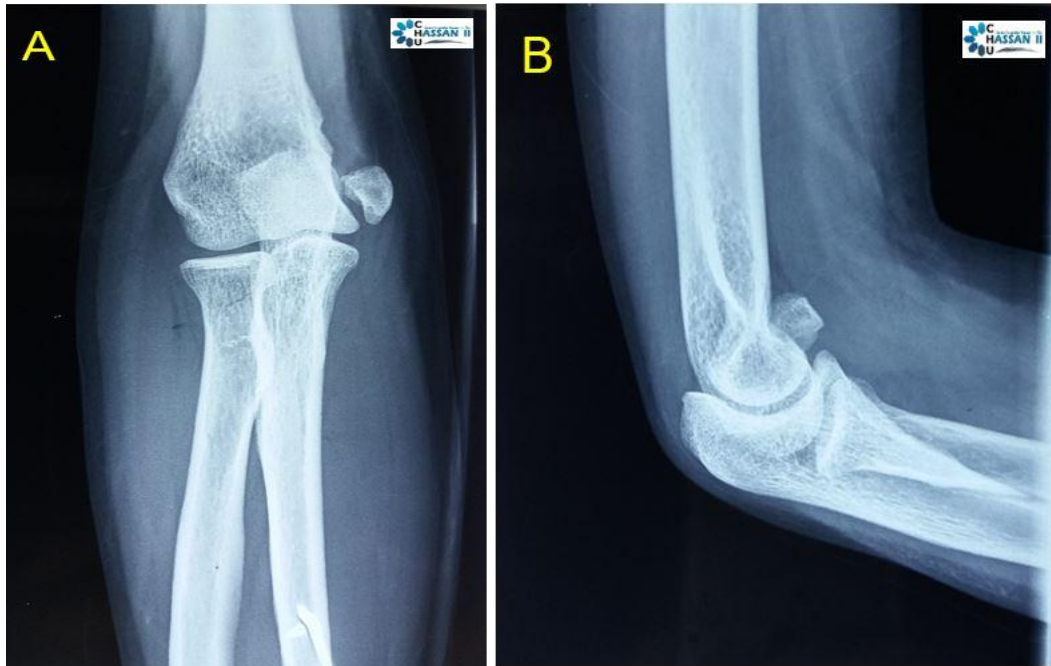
Standard frontal (A) and lateral (B) radiographs showed non-union of the medial humeral epicondylar fracture
